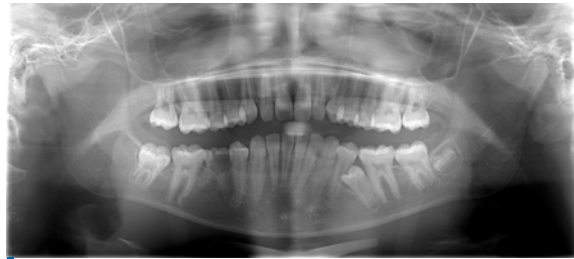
Orthopantomogram, OA.
